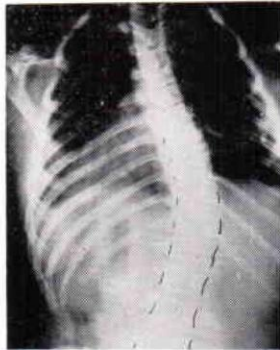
Spine at initial examination. Film made with patient standing, weight equal on both feet, knees straight. This is the x-ray of patient in Fig. 3, idiopathic scoliosis.
